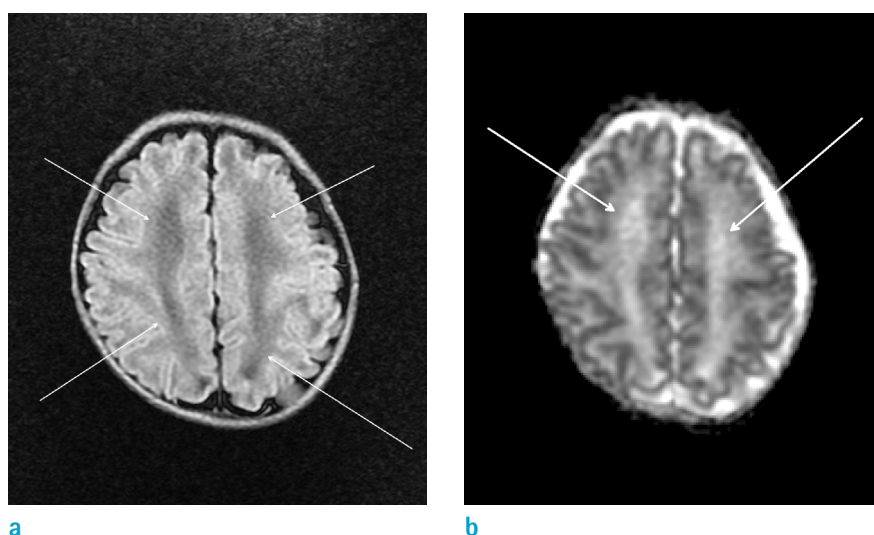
Axial FLAIR (a) and (b) ADC map showing DEHSI at the level of the centrum semiovale. This male infant was born at 30+5 weeks with a birth weight of 1250 g. MRI was performed at gestational age of 36+2 weeks. He showed accelerated mental development index and psychomotor motor index.
